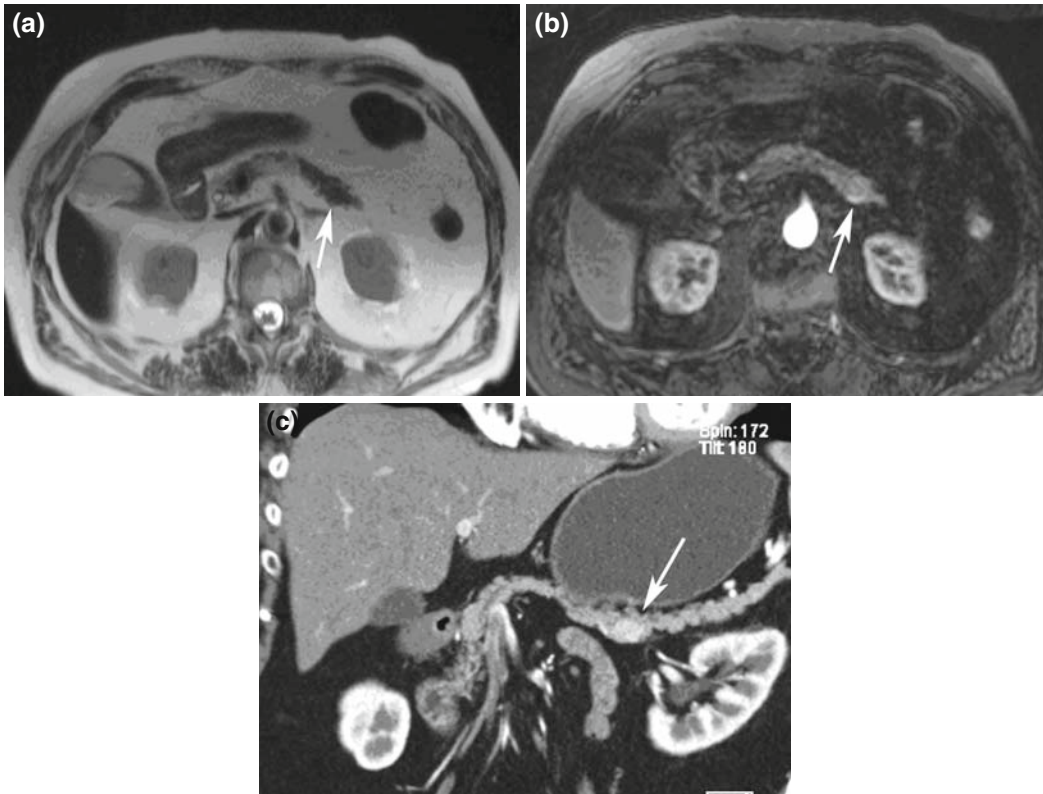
(A) Axial T2-weighted MRI image shows a contour deformation of the posterior surface of the pancreatic tail. The insulinoma is isointense to the surrounding pancreas parenchyma. (B) Arterial-phase gadolinium-enhanced T1-weighted MRI image shows the hypervascular insulinoma, slightly better demarcated from normal tissue. (C) Same patient, curved planar 3D reconstruction of an arterial phase-enhanced MDCT, which is superior to MRI in this case.
